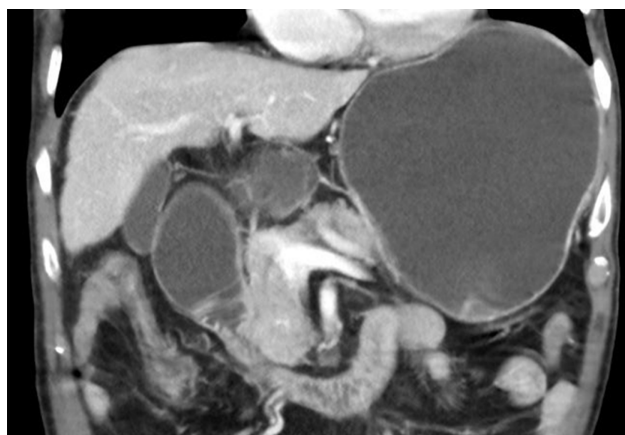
Computed tomography scan appearance of malignant duodenal stricture with gastric distension due to pancreatic cancer.
